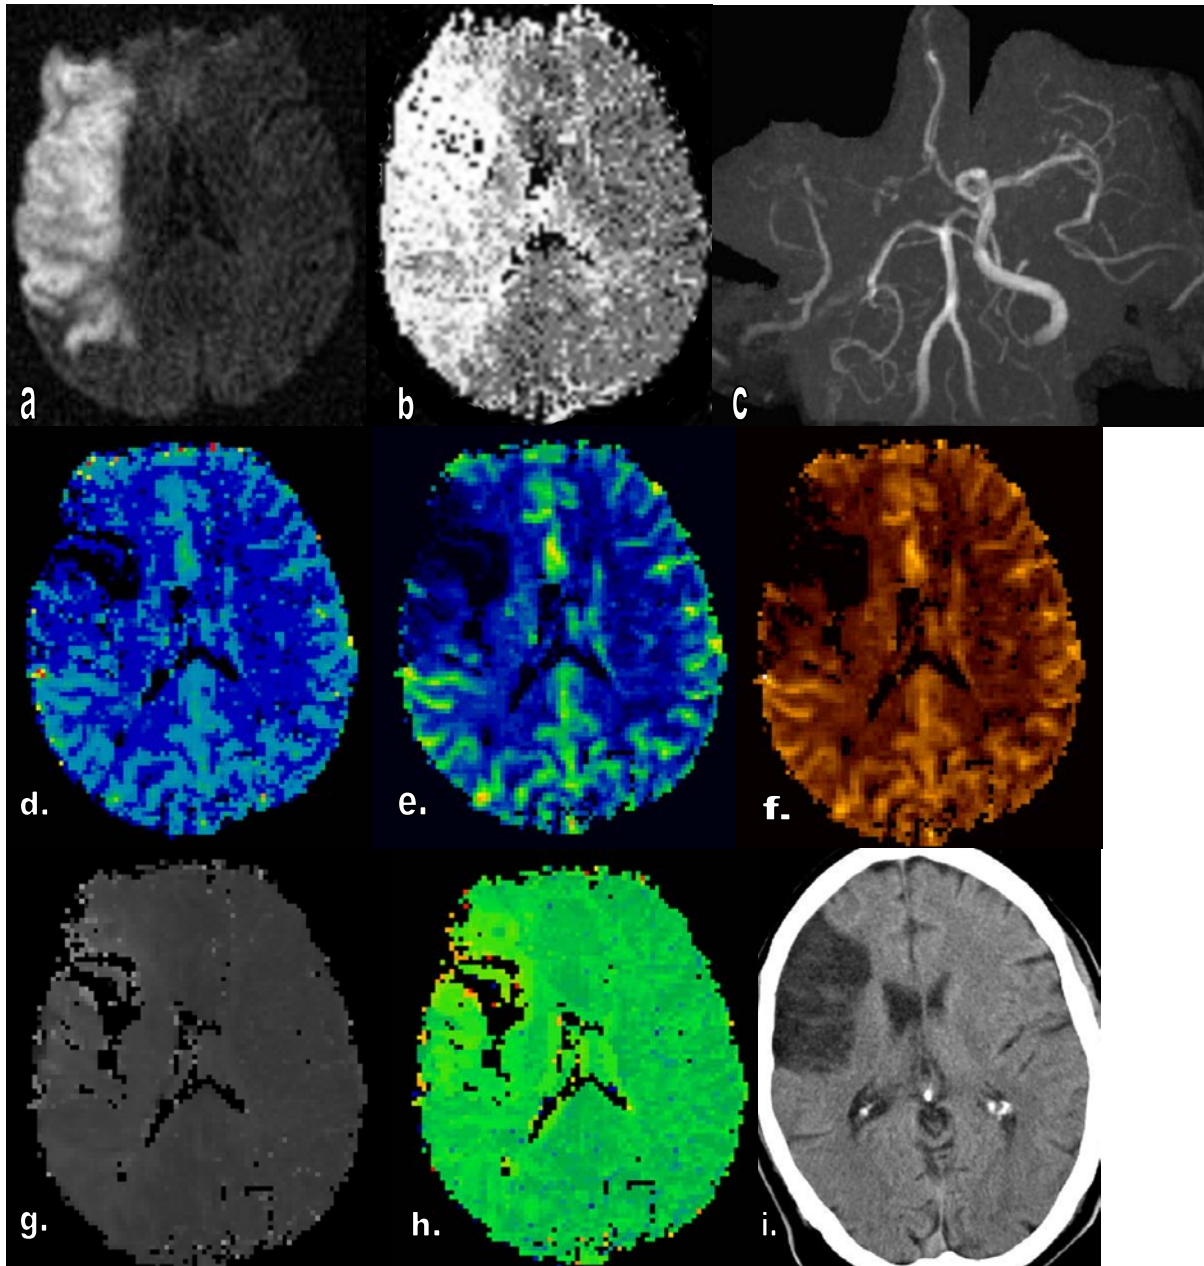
Patient M/62, aphasia and hemiparesis left. NIHSS score 14. Time to MRI scan 48 hours. a and b: DWI and PWI, both DWI and PWI showed an ischemic deficit on the right. A mismatch exists, with $1/2 < \text{volume of DWI} / \text{volume of PWI} < 1$. c. MRA showed a right carotid artery and MCA occlusion. d- h. rCBV, rCBF, MTT, TTP and T0 maps. In the ischemic core, rCBV and rCBF decreased by 55.6% and 67.1%, while in mismatch region rCBV and rCBF increased by 27.4% and 74.4% in comparison to the mirror region correspondingly. i. Follow-up (58days) CT confirmed that the size of the infarction was smaller than that on both DWI and PWI. The patient presented a clear recovery from hemiparesis and could move within the rolling-chair. MRS 4.
